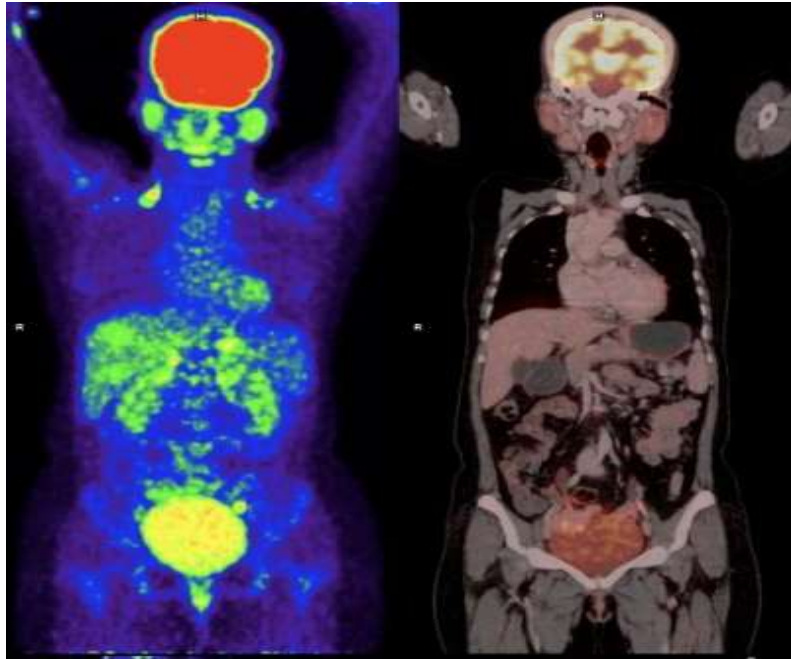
showing Multiple faintly FDG avid fairly well defined iso to hypo enhancing relatively hypo-dense lesions in both lobes of liver, largest lesion in segment VII / VIII measures 5.7 x 4.8 cms (SUV max 5.1) background uptake of liver 3.2. Correlative MRI shows predominantly T1 hyper-intense and mildly T2 hyper-intense lesions without restricted diffusion. - No other demonstrable FDG avid lesion or foci of restricted diffusion visualized in hepatic parenchyma
